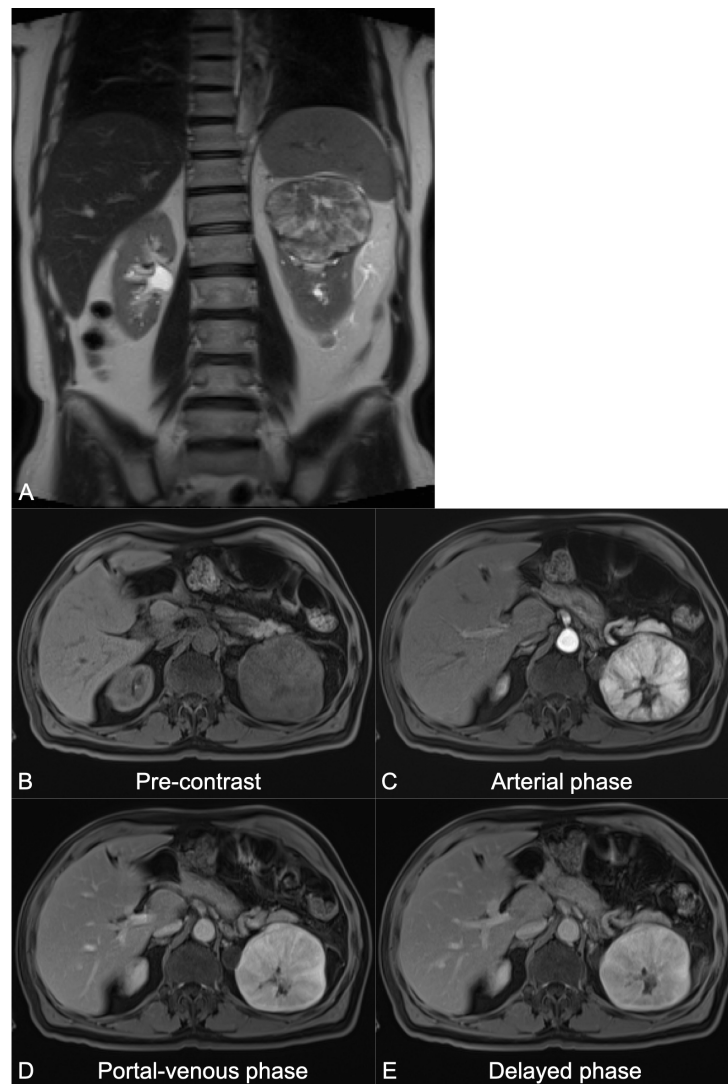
MRI with and without contrast of the abdomen and pelvis showing a suspected renal oncocytoma in the upper pole of the left kidney. (A) Coronal T2-weighted image; (B) Pre-contrast axial T1-weighted image; (C) Arterial phase (18 second post-contrast) axial T1-weighted image; (D) Portal-venous phase (2 minute post-contrast) axial T1-weighted image; (E) Delayed phase (5 minute post-contrast) axial T1-weighted image.
